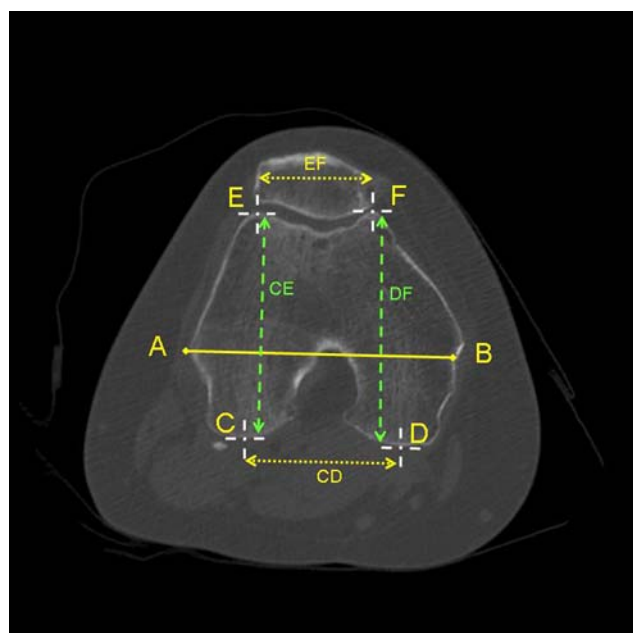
On this computed tomographic scan, the measurements of the distal femoral geometry are shown.
